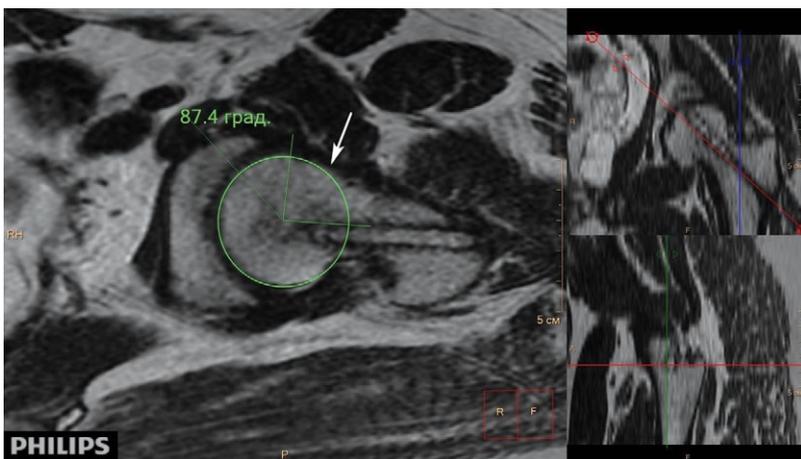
MRI of the left hip (oblique axial projection, T2 weighted image) of patient 18 years 2 months old, 4 years 7 months after surgery. Deformation of head-neck junction (indicated by an arrow) — lack of normal concavity of transition and increased anterior-superior angle α to 87.4°
